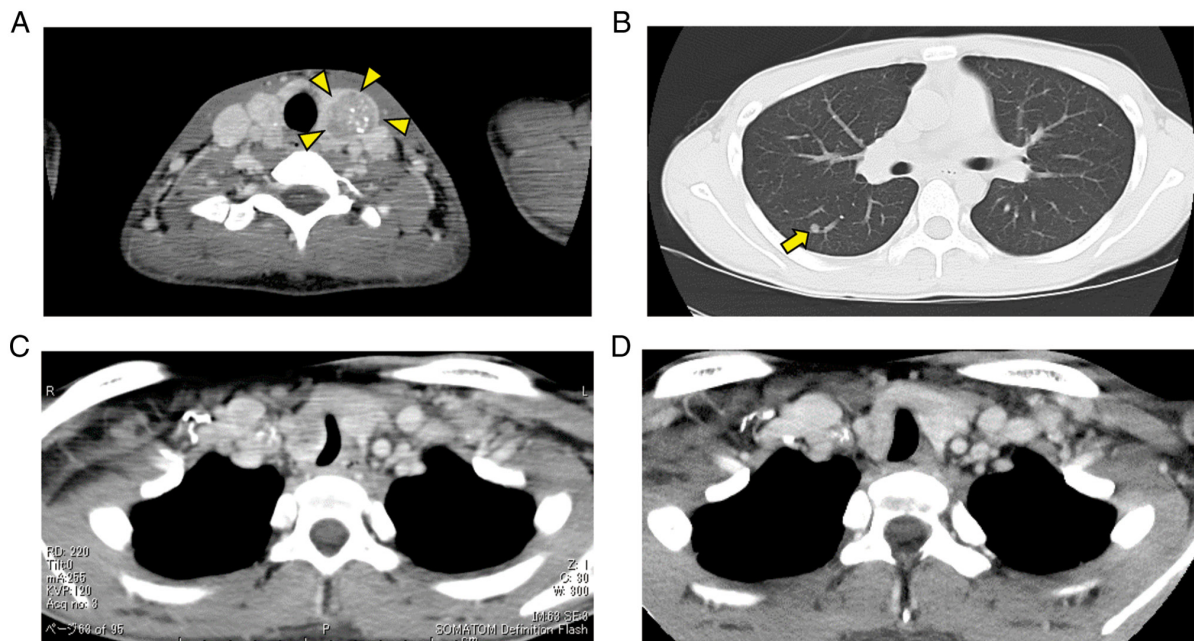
Computed tomography (CT) scan results of Case 1. (A) A thyroid tumor is shown (surrounded by arrowheads). (B) The CT scan demonstrates lung metastasis (pointed with an arrow). (C) The trachea was narrowed and deviated by the thyroid mass. (D) The CT scan shows an improvement in tracheal deviation in Case 1 after initiation of treatment.
